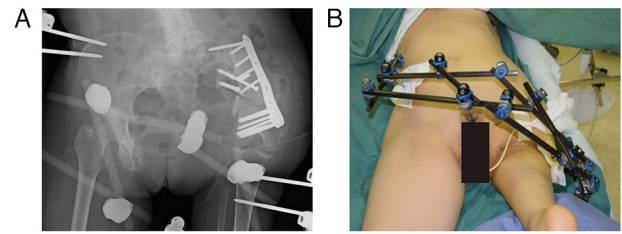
Postoperative radiograph and findings. (A) Postoperative radiograph. (B) External fixator is applied after open reduction and internal fixation.
